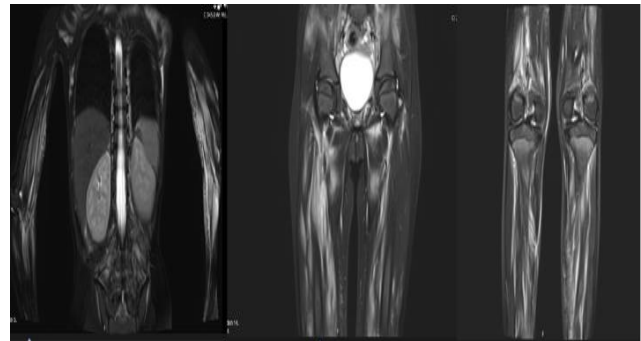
Whole body MR images. Widely T2A signal increases in both shoulders, both arms and forearm muscles, abdominal muscles, paravertebral muscles, bilateral thigh and crural muscles.
